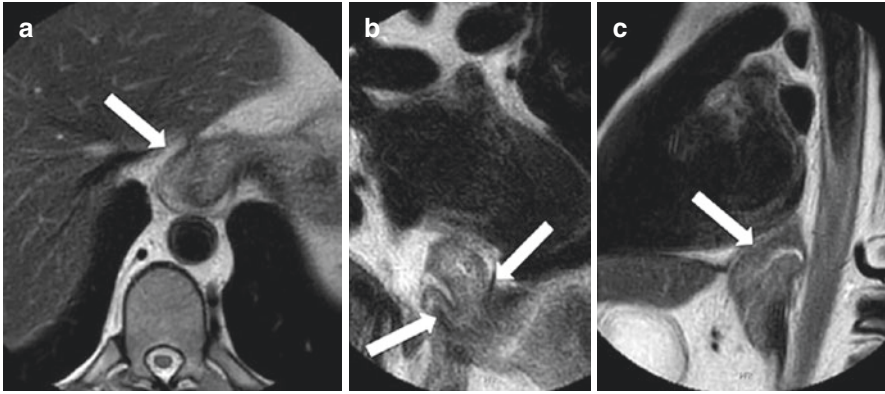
Slipped wrap on MRI. T2w-HASTE sequences in the axial view were performed to demonstrate the integrity of the wrap (arrow) (a). MR fluoroscopy in the coronal (b) and sagittal (c) view shows that the entire wrap (arrow) lies above the esophageal hiatus in a patient with post-prandial chest fullness. (Images courtesy to C. Kulinna-Cosentini, MD, Department of Biomedical Imaging and Image-guided Therapy, Medical University of Vienna)
